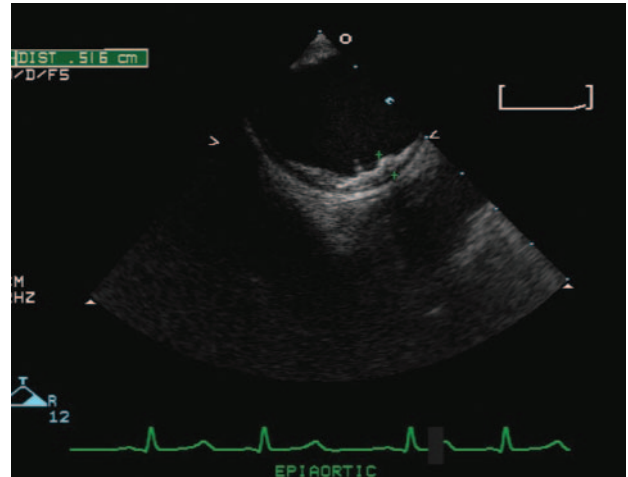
Ultrasound image of aortic atheroma.
